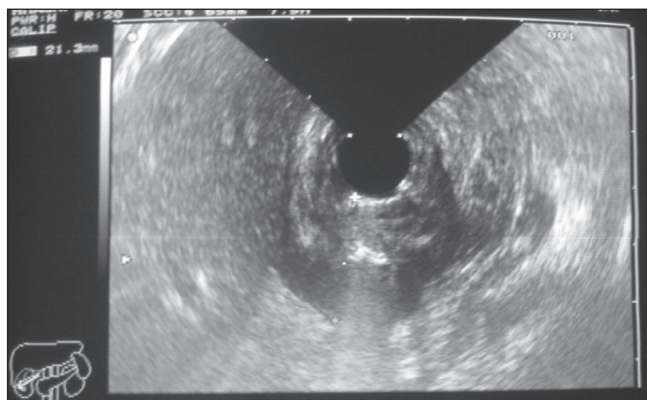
Radial endoscopic ultrasound image showing diffuse thickening of the antral wall (21 mm) involving mainly the submucosa and muscularis propria
